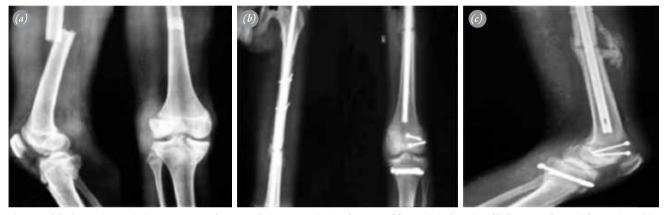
(a) Plain radiograph showing type IV fracture of the proximal tibia, fracture of femoral shaft and Hoffa fracture of lateral femoral condyle. (b, c) At final follow-up at 14 months all fractures united.
